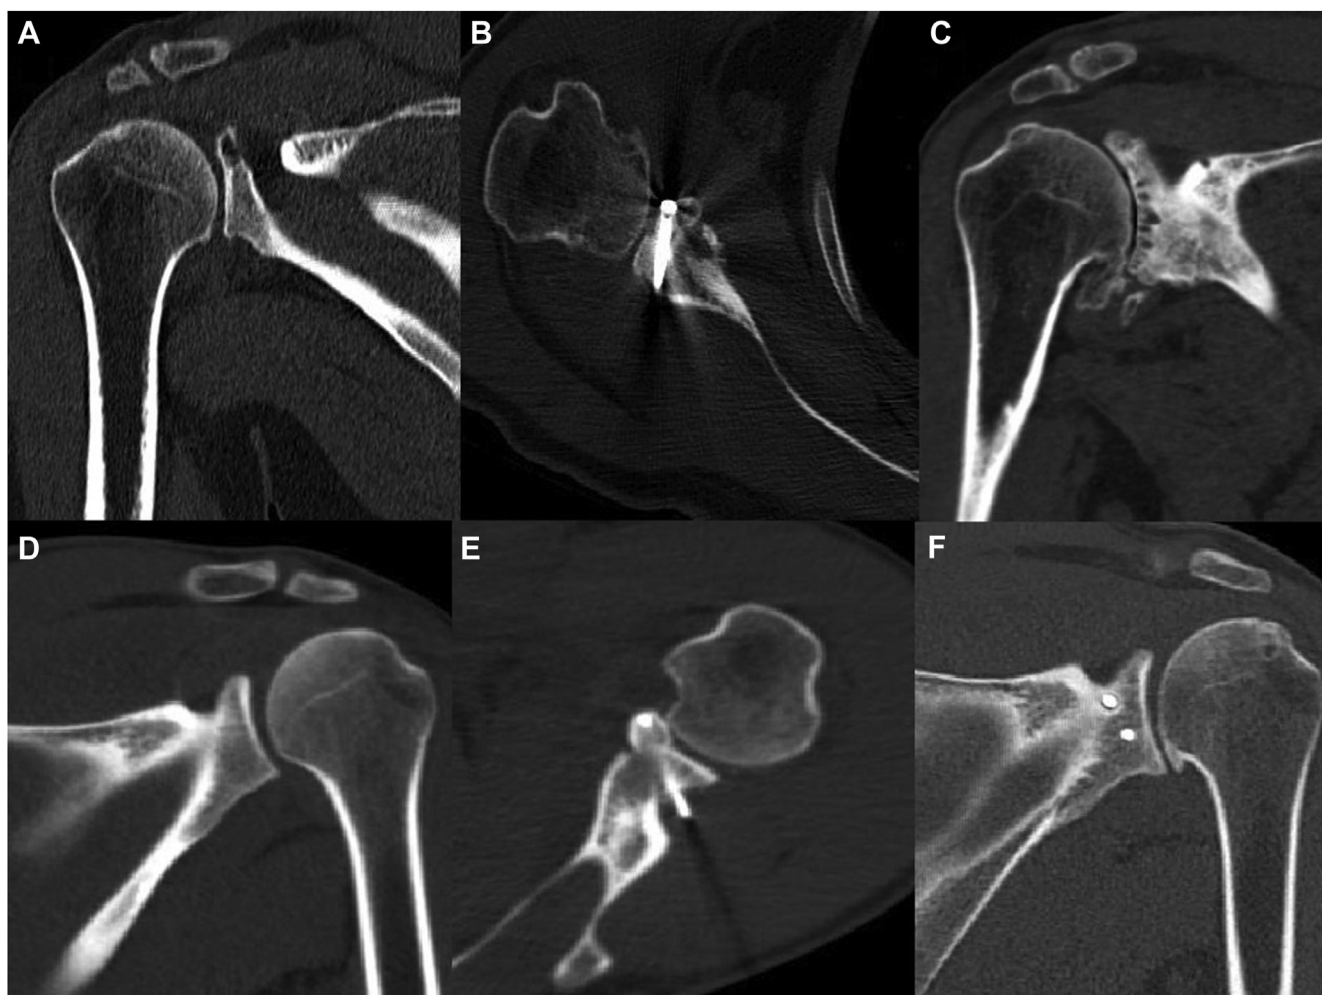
CT scan revealing progression of osteoarthritis related to technical errors. (A) Preoperative CT scan showing osteoarthritis grade 1; (B) Presence of intra-articular screw after Latarjet procedure; (C) Evolution to grade 4 osteoarthritis and screw removal; (D) Preoperative CT scan showing no presence of osteoarthritis; (E) Presence of lateral overhang position of the coracoid graft; and (F) Evolution to grade 2 osteoarthritis. CT, computed tomography.
